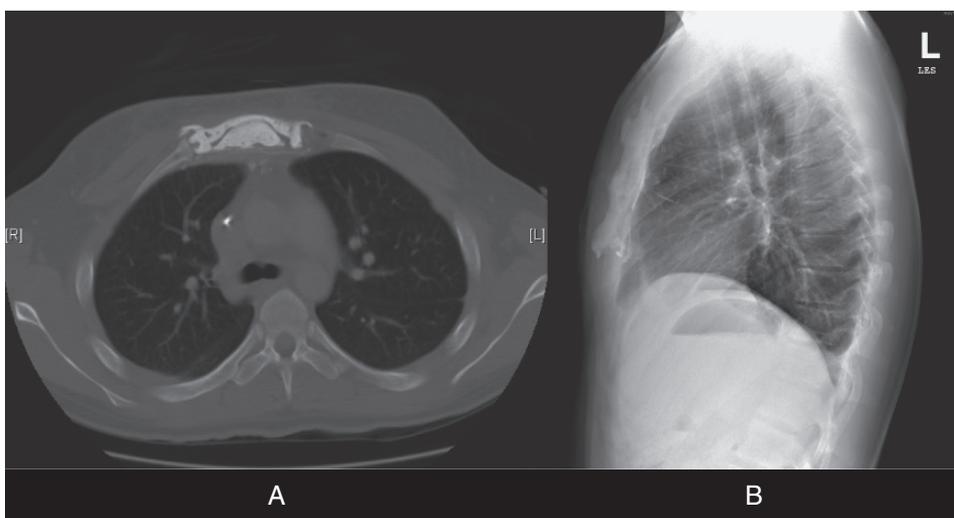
The result after upper sternal resection of the patient whose initial and postchemotherapy MRI is shown in Fig. 1. First, a polypropylene mesh patch was sewn to ribs, intercostals, and periosteum to provide a backing and close the sternal and chest wall defect. Then, a “neosternum” of methylmethacrylate cement was created in a .75-inch Penrose drain and attached to cement inserted into each cut end of the sternum. These ends were first hollowed out with a curette for approximately 2 cm from the end. Further cement was added behind the sternum to secure it to the mesh and to create attachments of two ribs.
